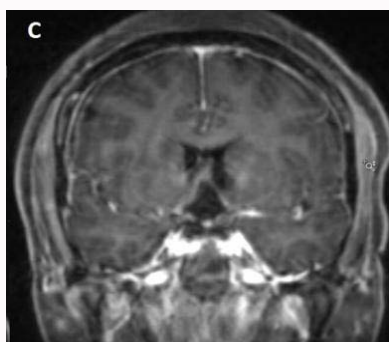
Post-operative MRI: Postoperative tumor assessment after transsphenoidal suprasellar tumor resection.
